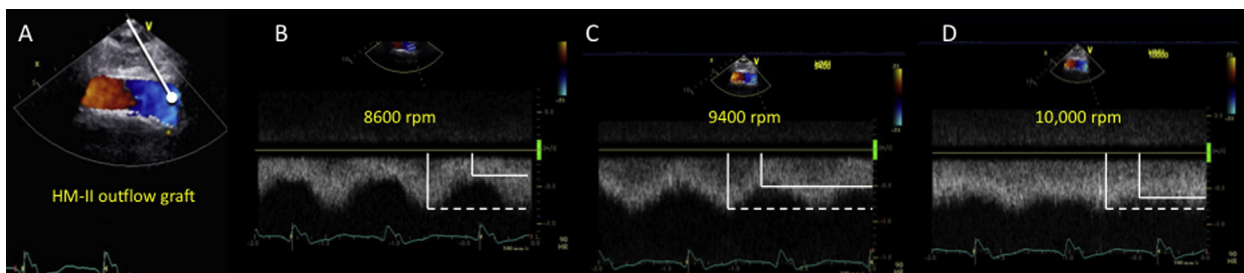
LVAD outflow graft, mid right parasternal window, on TTE. The flow velocity within the outflow graft should appear laminar, with a characteristic diminution of the peak systolic velocity (*dotted line*) and increase in the nadir diastolic velocity (*solid line*) as the pump speed is systematically increased (narrowing of the pulse pressure). *Note:* A similar diminution of the peak systolic velocity and increase in the nadir diastolic velocity occurs as the pump speed is systematically increased in the absence of any provoked inflow obstruction. See also [Video 33](#).
